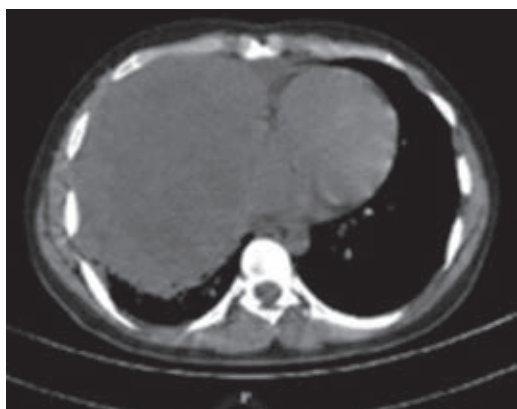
Chest CT simple axial window with a hyperdense mass in the right hemithorax, occupying almost its entirety.
